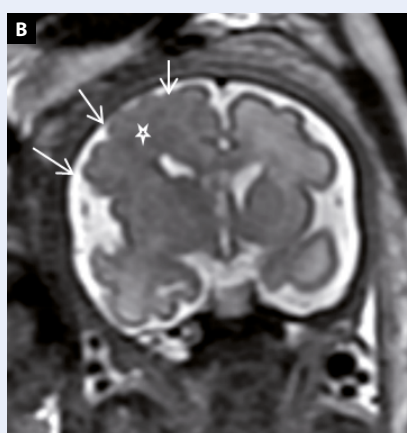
Hemimegalencephaly. Coronal view of the fetal brain showing an overgrowth of the right hemisphere and abnormally developed sulci and gyri (arrows): (A) transabdominal 2D ultrasound view at 24 weeks; (B) fetal MRI at 29 gestational weeks; SSFSE/T2, coronal plane, apart from abnormally developed sulci and gyri (arrows) hypointensity of the right cerebral white matter (asterisk) as a sign of migration abnormality is visible; IF — interhemispheric fissure; FH — frontal horn
